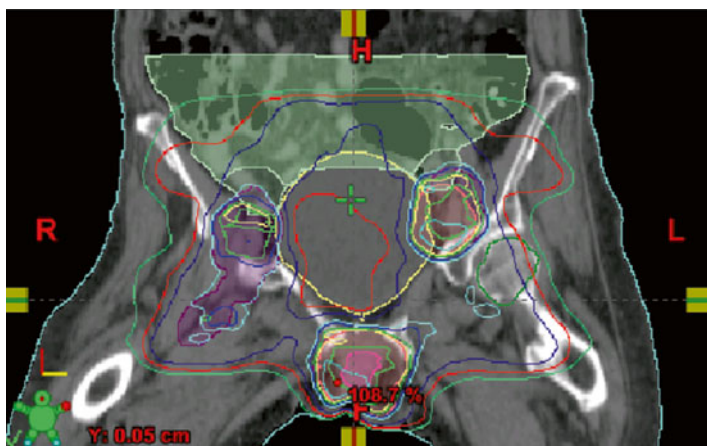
Coronal CT view of an image-guided IMRT plan for vulvar cancer. Image courtesy of C. Yashar.
